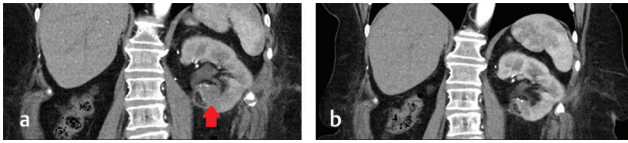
(a) Arterial phase CT with coronal reformats 6 months after hybrid treatment showed no residual enhancement and mild shrinkage of the tumor scar (arrow). (b) Portal venous phase CT with coronal reformats 13 months after hybrid treatment showed significant shrinkage of the tumor scar (arrow).
